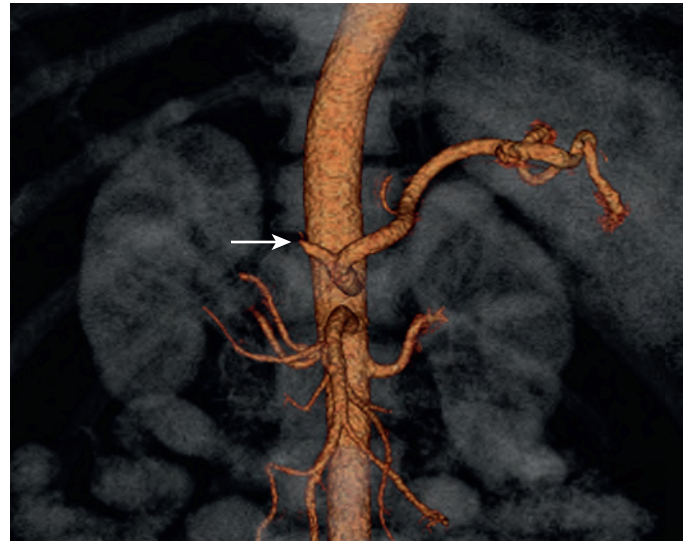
Hepatic artery thrombosis. CT angiogram of a patient after OLT shows occlusion of the main hepatic artery (arrow).
